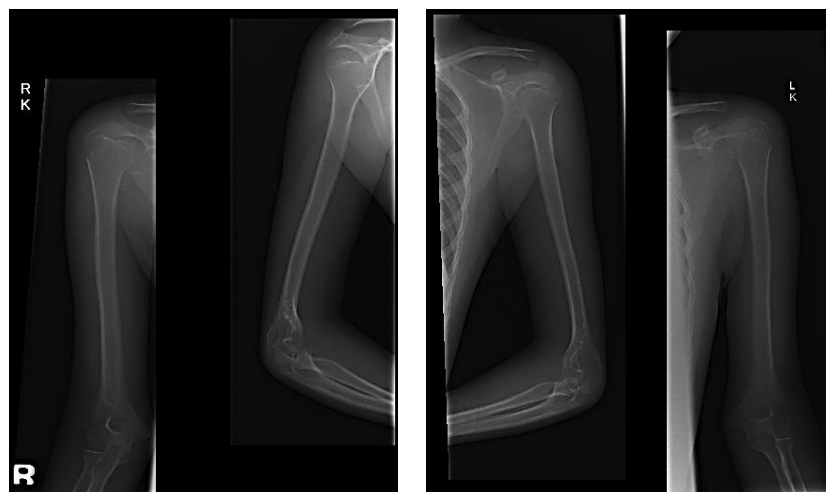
Left: X-ray photo of the right elbow; Right: X-ray photo of left elbow.
